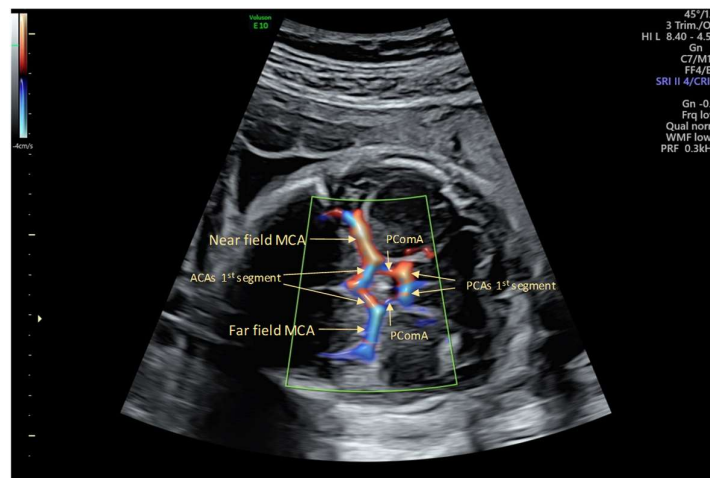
Colour Doppler image of cerebral arteries imaged with contemporary ultrasound equipment. The orientation of the middle cerebral arteries (MCA) enables these vessels to be readily identified at an optimal angle of insonation for reproducible measurements. The first segment of the anterior cerebral arteries (ACAs), posterior cerebral arteries (PCAs) and posterior communication arteries (PComA) complete the Circle of Willis. Image produced by D Paoletti.
